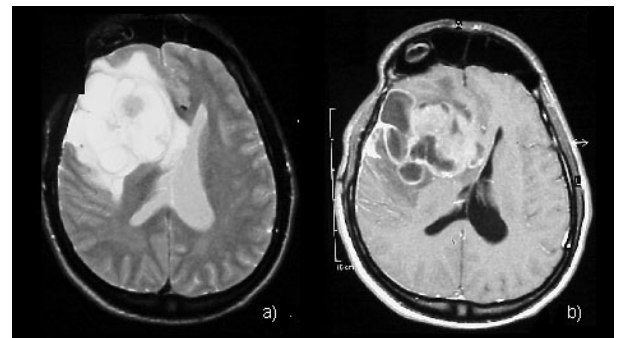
Magnetic Resonance axial sections of the same right fronto-insular glioblastoma: a) T2-weighted section; b) T1-weighted section after contrast medium injection.
